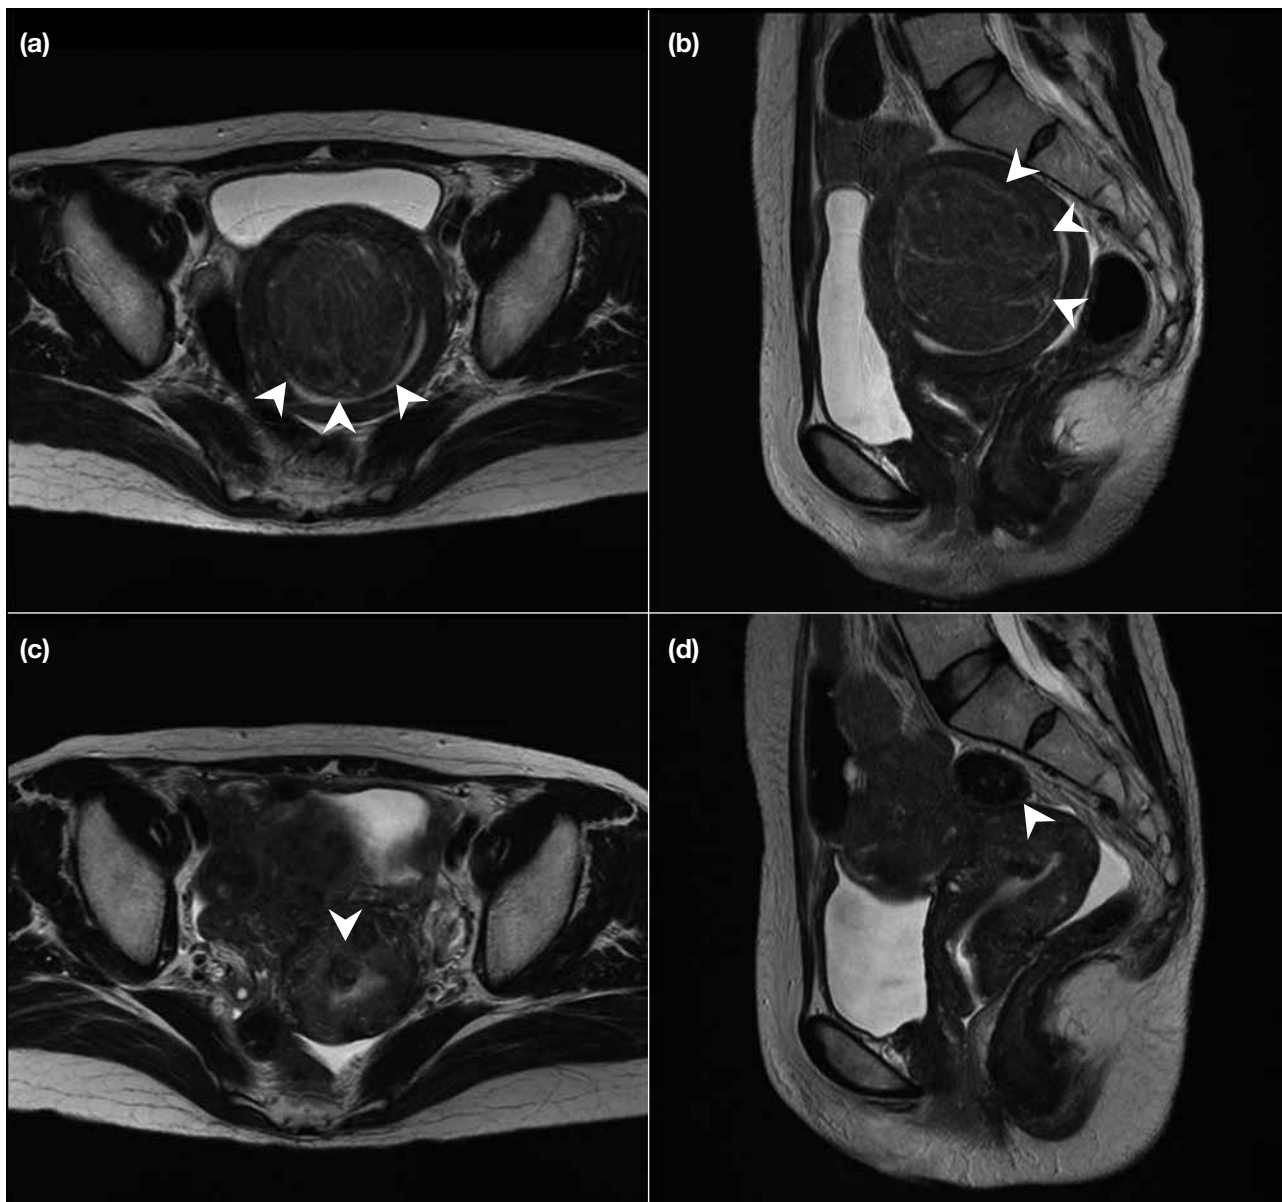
(a) Axial and (b) coronal T2-weighted magnetic resonance (MR) images showing a large T2 hypointense submucosal fibroid with distension of the endometrial cavity (arrowheads). (c) Axial and (d) coronal T2-weighted MR images 1 month after UAE. This patient experiences fibroid expulsion. Previous fibroid has almost completely disappeared with only small residual T2 hypointense stalk left (arrowheads). Endometrial cavity distension has markedly improved.
